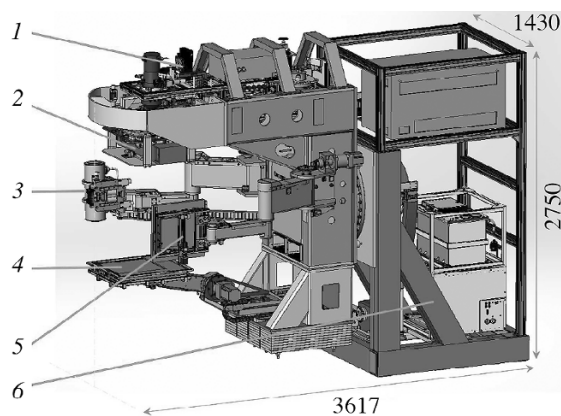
Contents of the interior units of the KLT-6 system: 1) gantry with 5 cm wavelength range accelerator; 2) multi-leaf collimator; 3, 4) x-ray tube and x-ray detector of the cone-beam computer tomography system; 5) bremsstrahlung detector; 6) mount with solid-state modulator.
